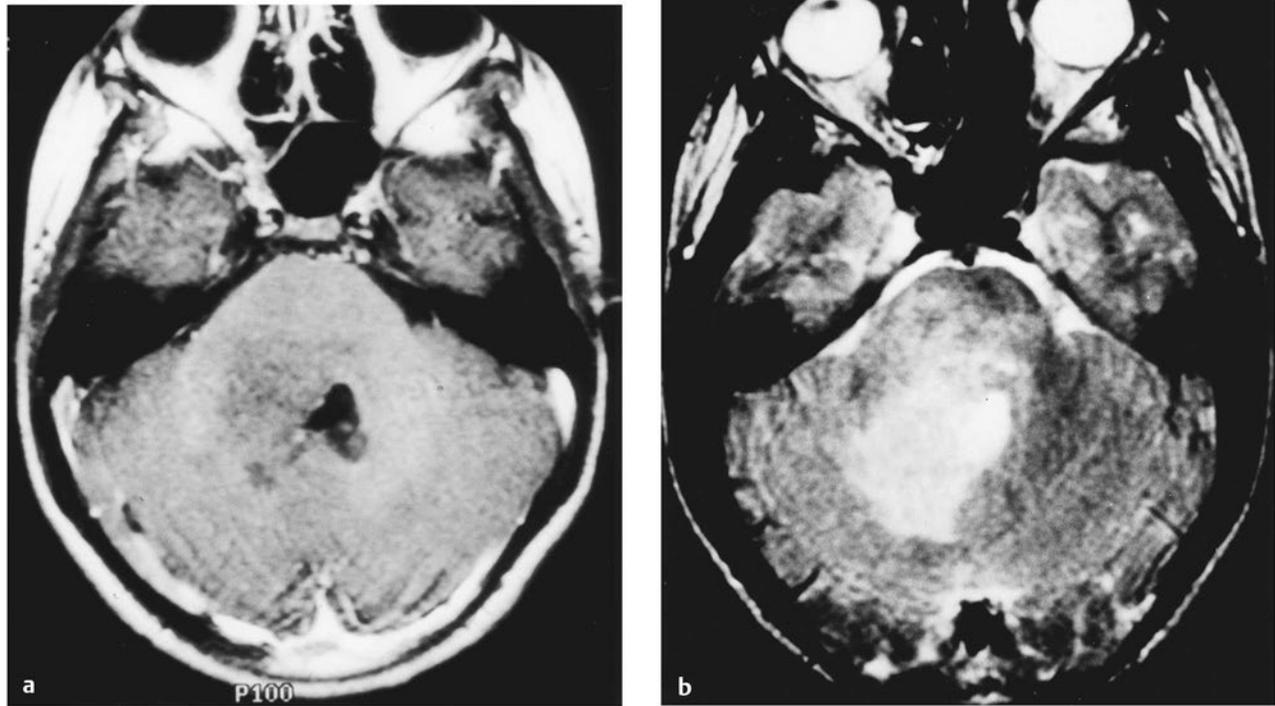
These magnetic resonance images demonstrate a common imaging abnormality in patients with neurofibromatosis 1 (NF-1). The brainstem is diffusely enlarged with (a) decreased T1 signal intensity and (b) increased T2 signal over a wide area centered at the cerebellar peduncle, in some ways resembling the appearance of diffuse intrinsic tumors in patients without NF-1. This patient, shown here at 16 years of age, initially manifested with a right facial paresis and dysarthria secondary to palatal insufficiency at age 4. No imaging evidence of tumor progression was detected during a follow-up interval of 12 years.
